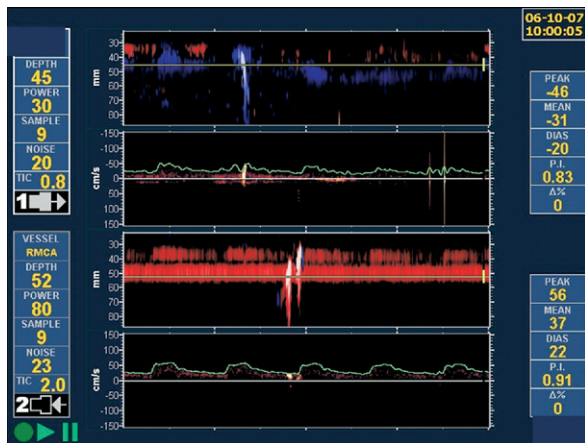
online only. On transcranial Doppler (TCD) monitor a microembolic signals (MES) recorded on channel 1 in the submandibular internal carotid artery (SICA) is seen after a delay of a single heart beat in the middle anterior cerebral artery (MCA) by transtemporal transcranial Doppler (TCD) probe on the lower channel 2.
